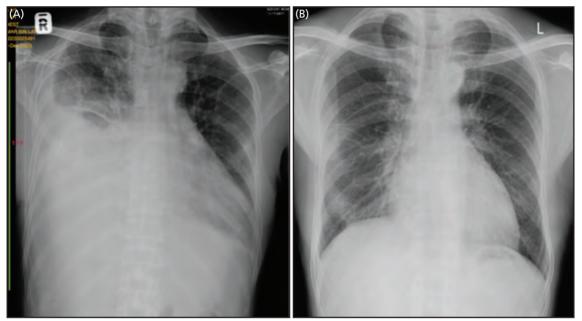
(A) Chest radiograph on admission showing a massive right-sided pleural effusion. (B) Follow-up chest radiograph during clinic review demonstrating complete resolution of the right pleural effusion
